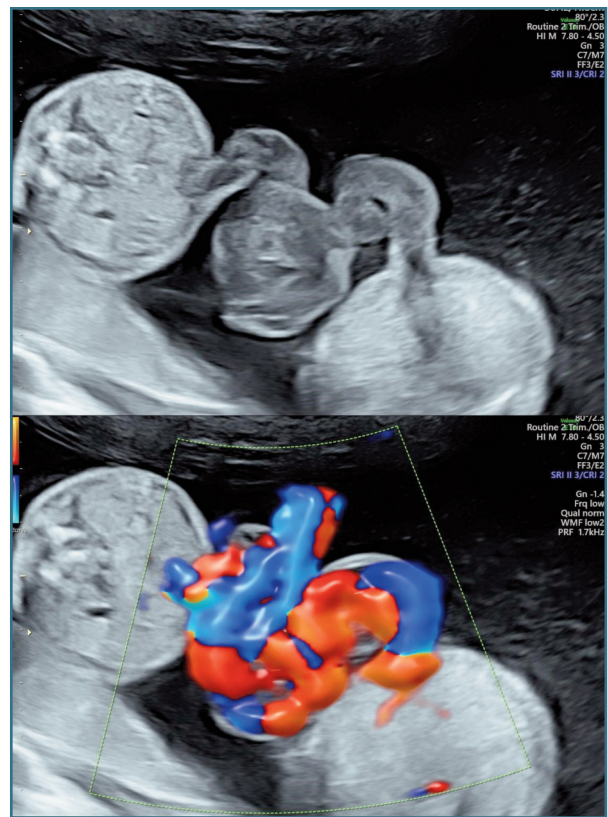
Ultrasound image of umbilical cord entanglement between the fetuses.
